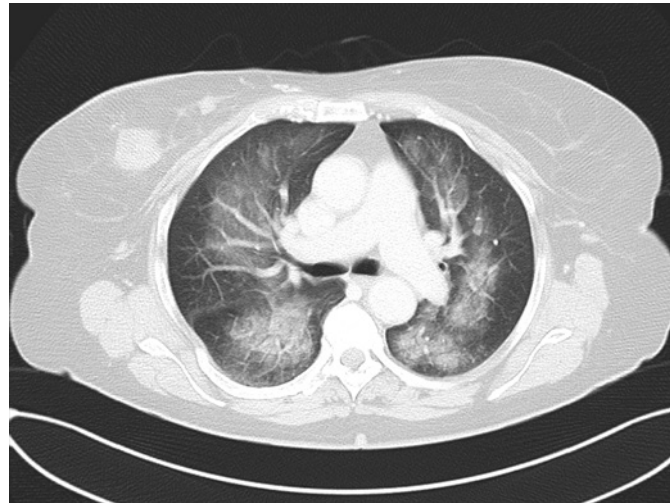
CT angiogram of the thorax performed during hospitalization, revealing aggravation of the extent of DAH.
